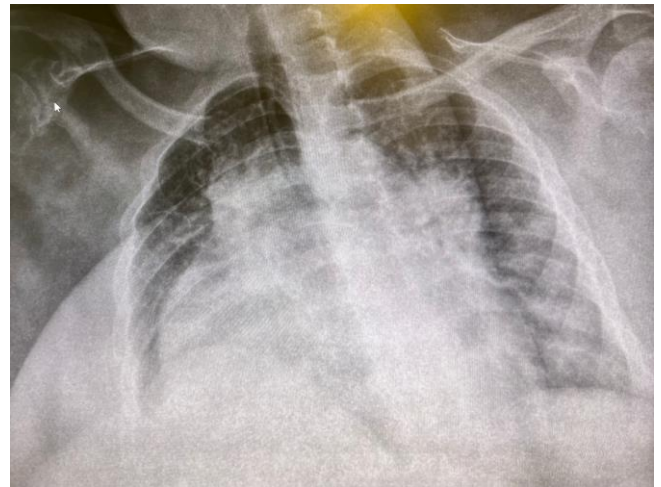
Second Chest X-ray of Patient During Admission
